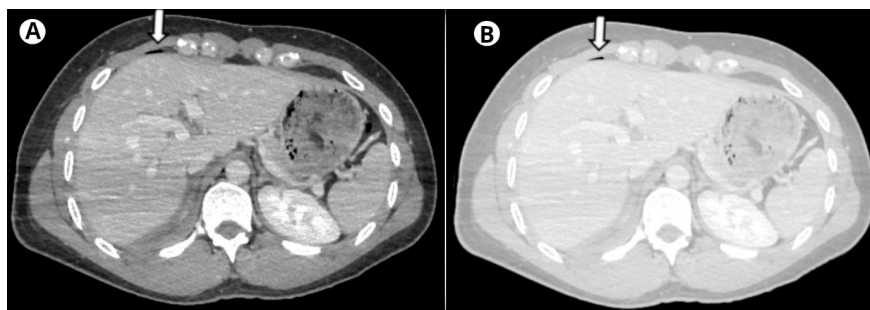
Computed tomography (axial view) in a soft tissue window (2A) and lung window (2B) shows a small pocket of air (arrow) in the right sixth intercostal space anterior to the liver.
